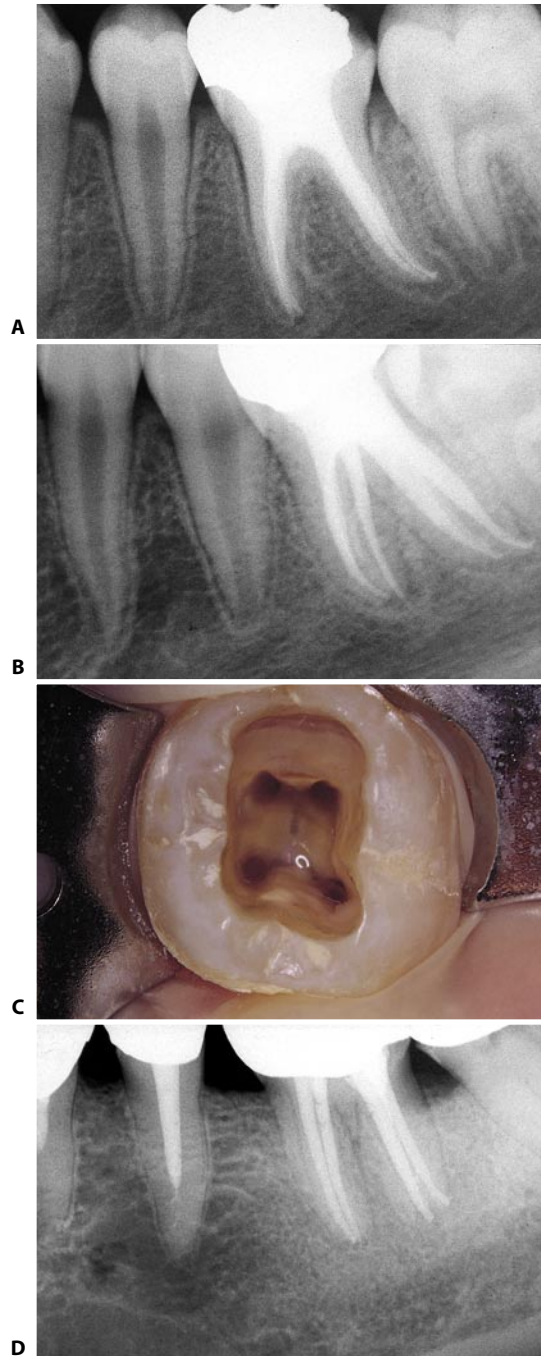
A. Postoperative radiograph of the lower first molar. B. This mesiodistal view of the same tooth demonstrates, in addition to the two canals of the distal root, the mesial canals which, although they communicate with each other at the level of the middle one third, have independent apical foramina. C. Access cavity of a lower left first molar with two canals in the distal root and two canals in the mesial root. D. In this other lower molar the four canals in the two roots are visible, each with an independent apical foramen.
